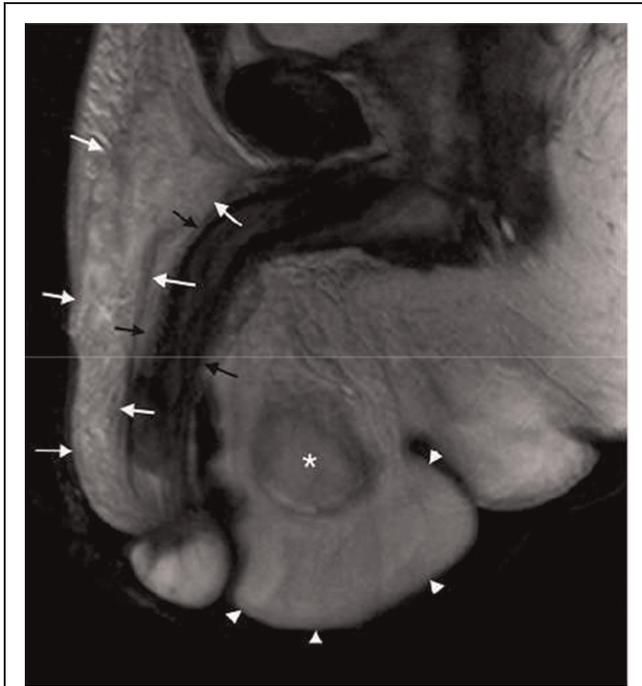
Case 1: T2 weighted spin echo sagittal magnetic resonance imaging. The oil is high signal and can be difficult to distinguish it from subcutaneous fat. However, note how the dorsum of the penis is asymmetrically thickened by high signal material lacking the normal lobulations of fat (white arrows). Black arrows mark the low signal tunica albuginea of the corpora cavernosa. There is associated marked scrotal lymphoedema (white arrowheads) around a normal testis (asterisk).
